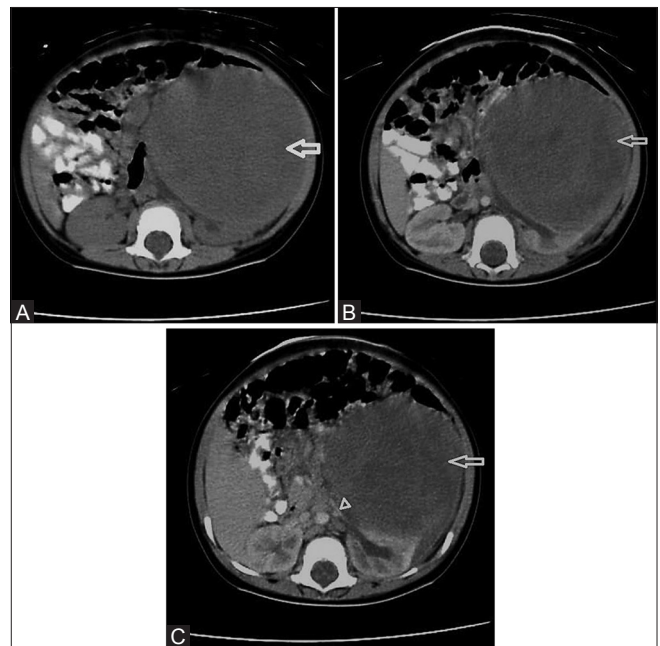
(A-C): (A-C) Plain, arterial, and venous phases of axial abdominal CT showing a heterogeneous mass with minimal contrast enhancement on the left side of the abdomen (arrow) compressing the left renal vein (arrowhead)
